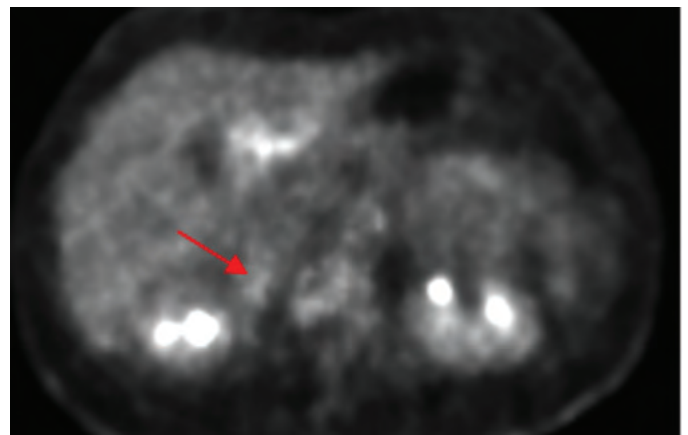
FDG-PET/CT showing minimally increased focal FDG uptake at the central part of the lesion (arrow)
